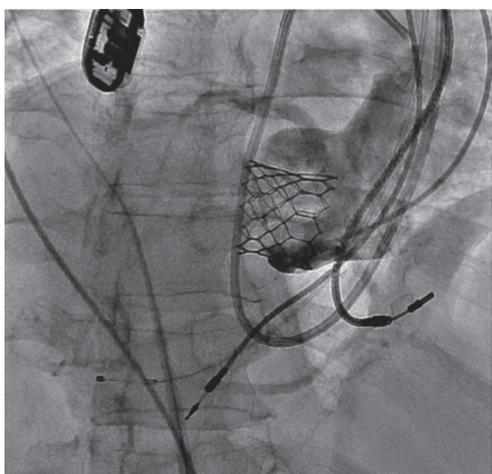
X-ray image during TAVI showing prosthetic valve deployment.
